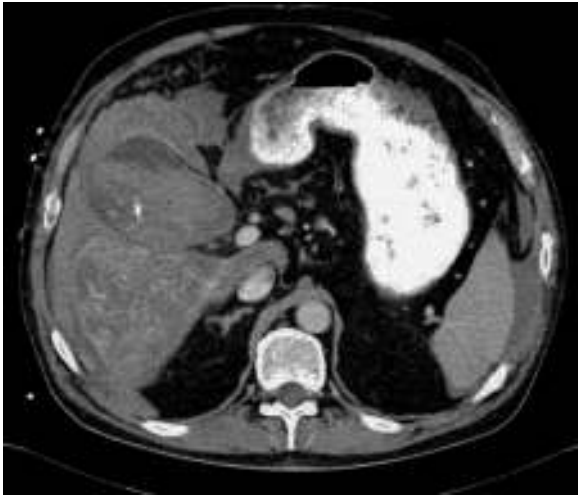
Abdominal CT scan: haemocholecystitis; active extravasation of gallbladder contrast.
